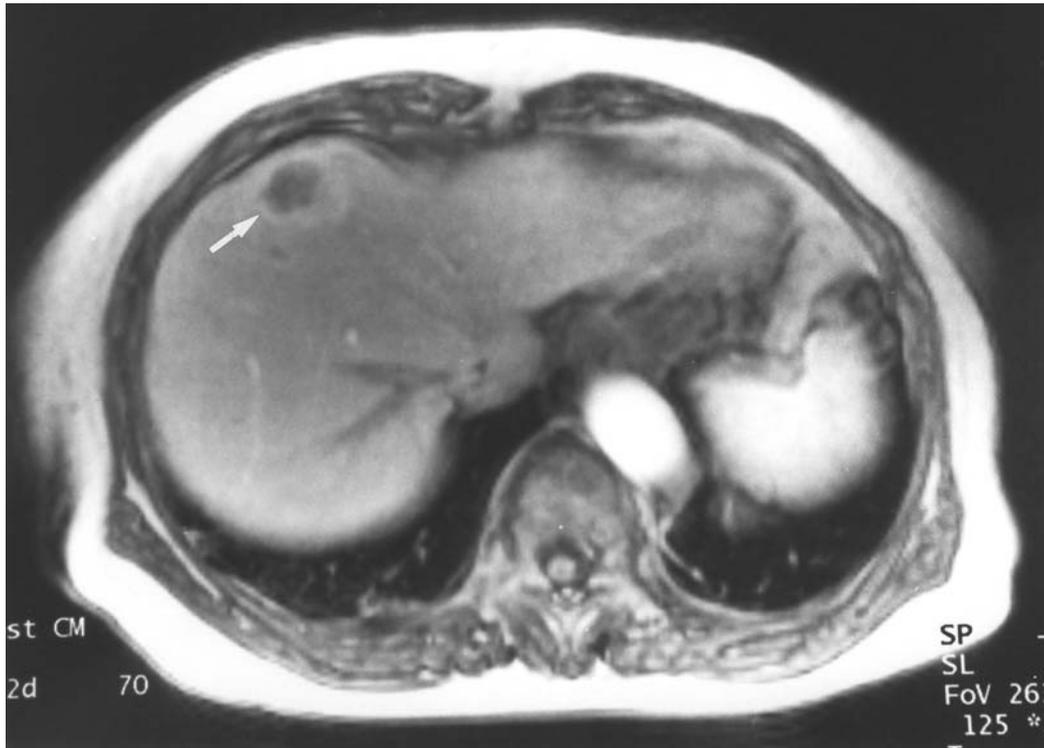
MR image of the abdomen demonstrated liver metastasis.
